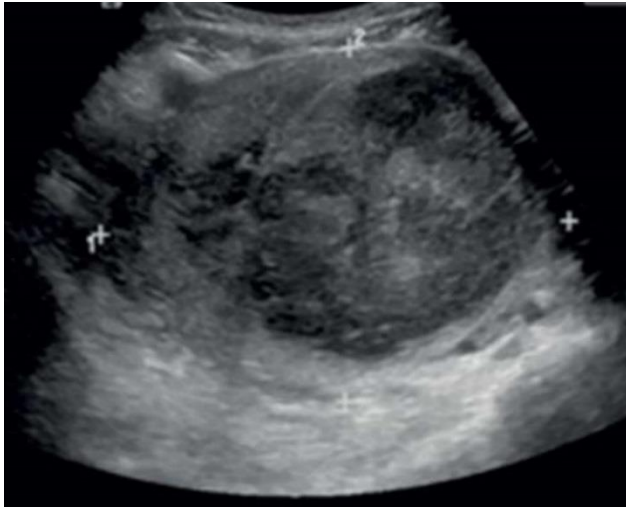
Ultrasonography of pelvis
